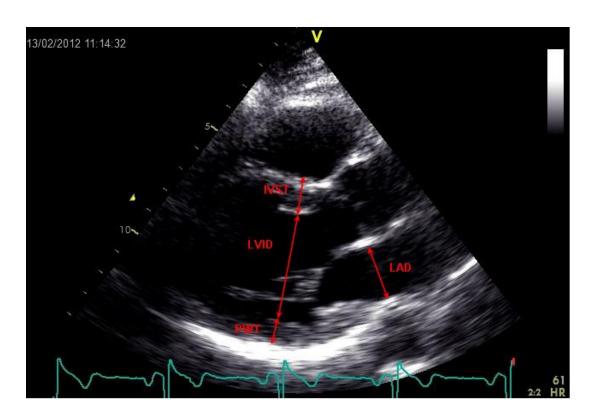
1 LV Standard Parasternal Long Axis view. IVST: interventricular septal thickness, LVID: left ventricular internal diameter, PWT: posterior wall thickness, LAD: left atrial diameter
